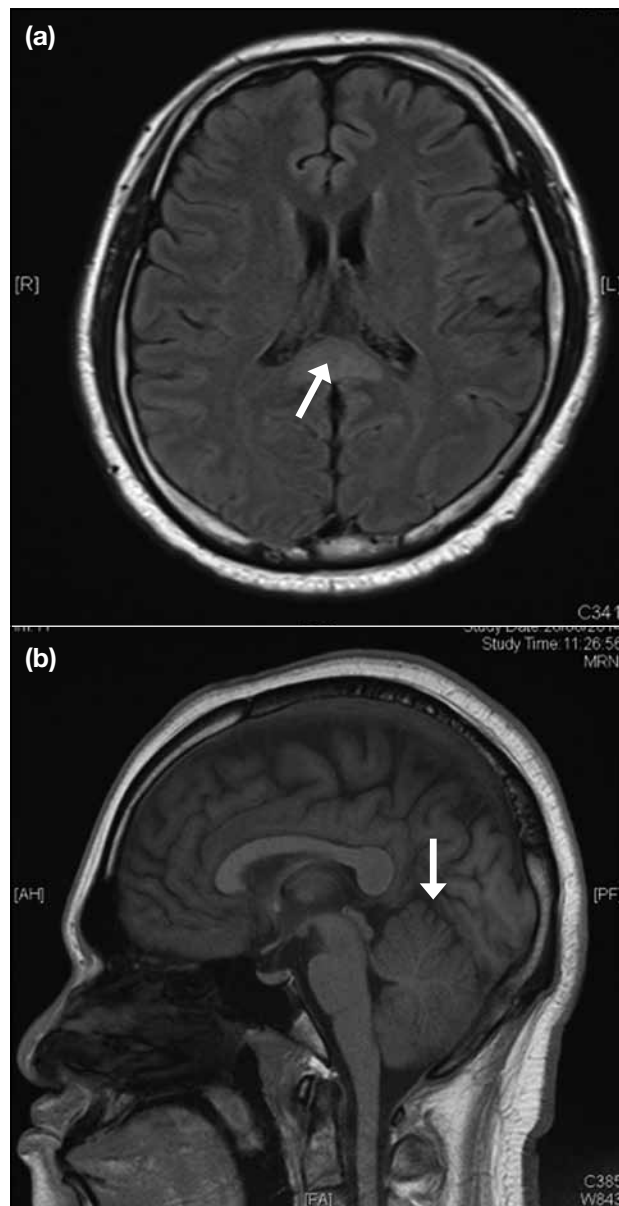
Magnetic resonance images of a patient with mild encephalitis / encephalopathy with a reversible splenial lesion. (a) Fluid-attenuated inversion recovery hyperintense signal at the splenium of corpus callosum (arrow), and (b) T1-weighted sagittal image shows a swollen cerebellum with mild T1 hypointensity (arrow).
